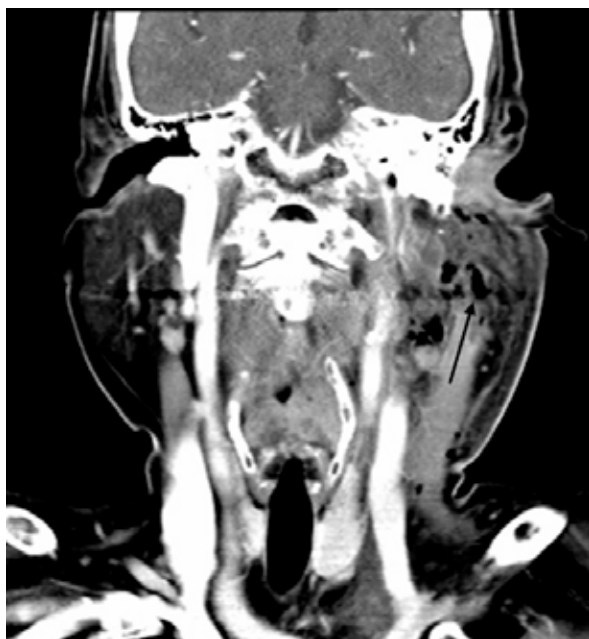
Coronal CT scan of a patient diagnosed with left mastoid abscess and Bezold's abscess (arrow)
